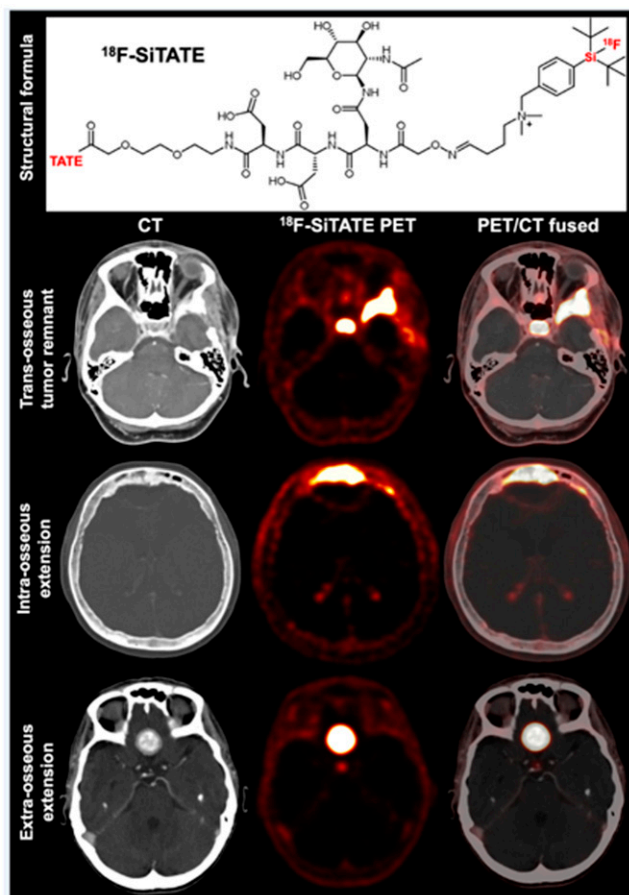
Next-generation PET/CT imaging in meningioma with ^{18}F -SiTATE. Top: Structural formula for the somatostatin receptor-targeting peptide ^{18}F -SiTATE. Bottom rows: Example high-contrast images (left to right: CT, ^{18}F -SiTATE PET, and PET/CT fused) showing (top) transosseous extension, (middle) transosseous extension, and (bottom) extraosseous extension. More than a fourth (27.1%) of the meningioma lesions identified on ^{18}F -SiTATE in this large study were not clinically suspected or detected on conventional imaging.
